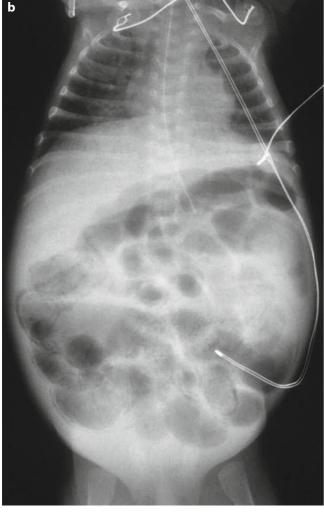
Radiographic appearance of pneumatosis intestinalis with bubbly gas pattern (a) and linear gas collections in the bowel wall (b)
